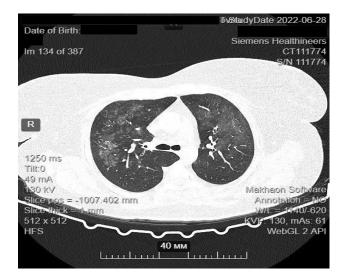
CT scan of the patient with COVID-19 infection in anamnesis, the scan shows ground glass opacification of both lungs with 35-40% lung involvement.
